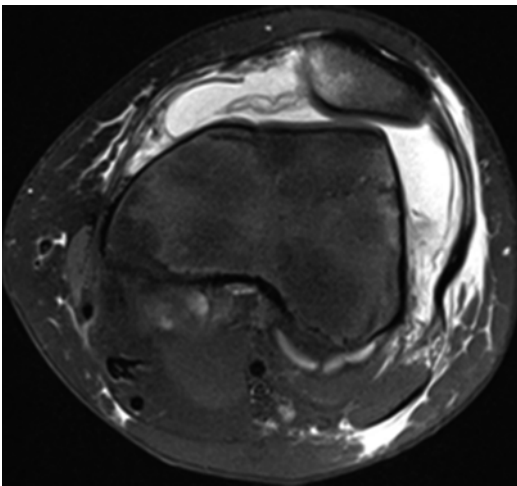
Midsubstance lesion of the MPFL visible on MRI axial views
